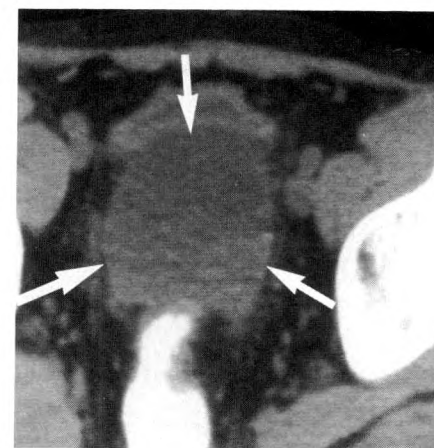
22-year-old man with increasing abdominal pain and fever. Barium enema and upper gastrointestinal series demonstrated abnormal bowel but no evidence of abscess. CT shows abscess above prostate and bladder (arrows). Treatment was conservative with antibiotics; subsequent CT scans showed resolution of abscess.
